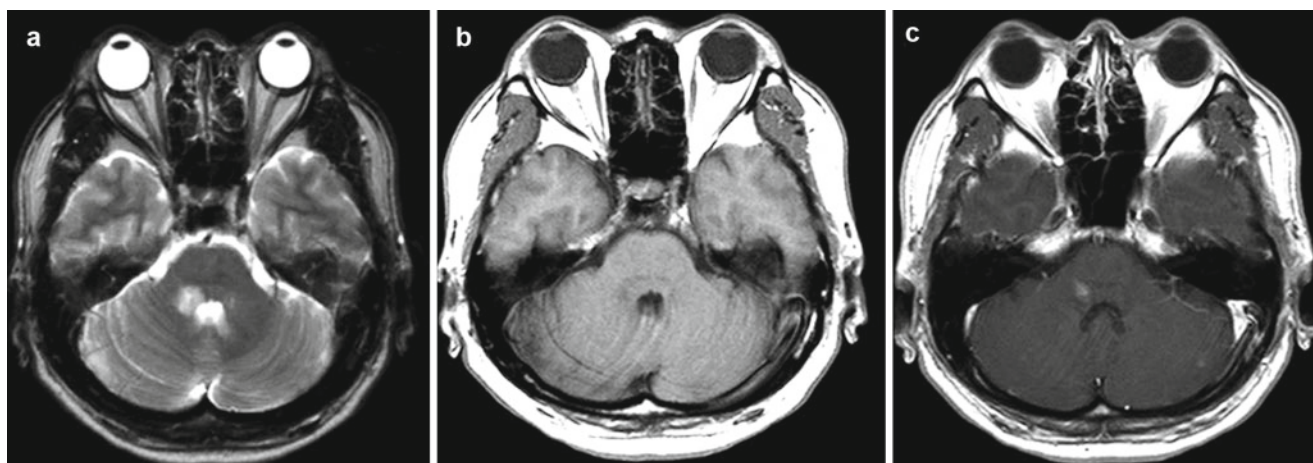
Toxoplasma* meningitis. Note the small localized lesion in the pons with inhomogeneously high intensity signal on T2-weighted (a) and a hypointense signal on T1-weighted (b) images. There is also a patchy contrast enhancement (c)
